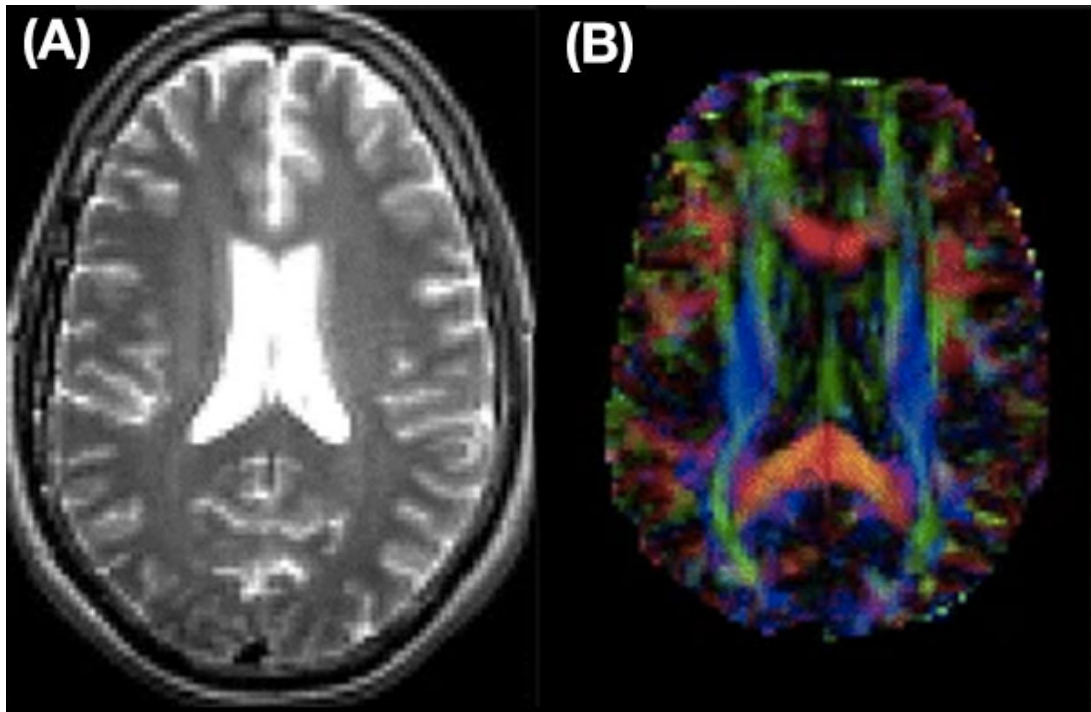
Standard MRI structural scans of the brain include (A) T1-weighted anatomical scans and (B) diffusion tensor imaging (DTI) scans, which indicates general fiber direction of white matter by colorization. *Adapted from Assaf, et al. 2008 [153]*
